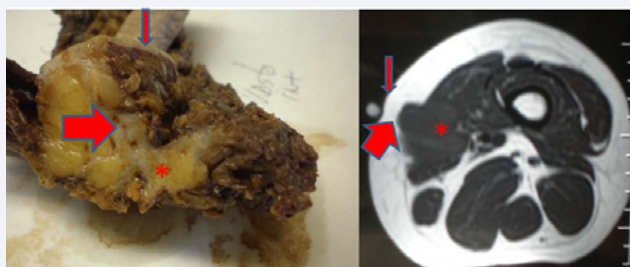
Local recurrence: MRI and macroscopic piece, Asterisk: Local Recurrence, Thick arrow: Contamination of the biopsy track, Thin arrow: Skin.
